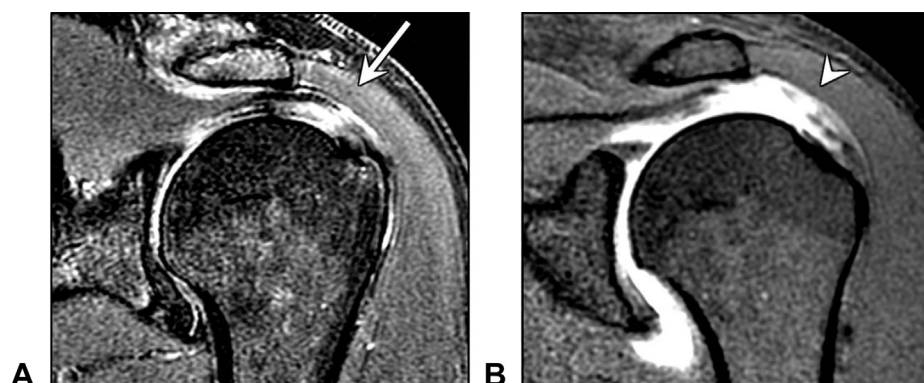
MRI of a 45-year-old man with a small tear that progressed without symptoms over the course of 1 year. A An asymptomatic small tear (arrow). B Depiction of tear enlargement with time (arrowhead).
